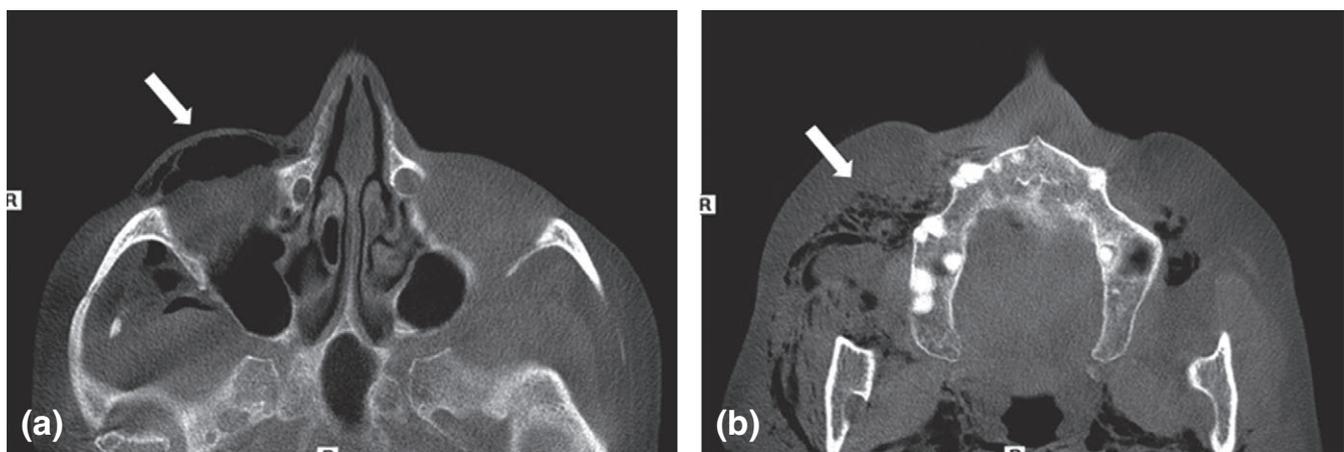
Axial image of the cone-beam computed tomography showing (a) peri-orbital emphysema and (b) multiple air bubbles in the malar and masseteric regions.
